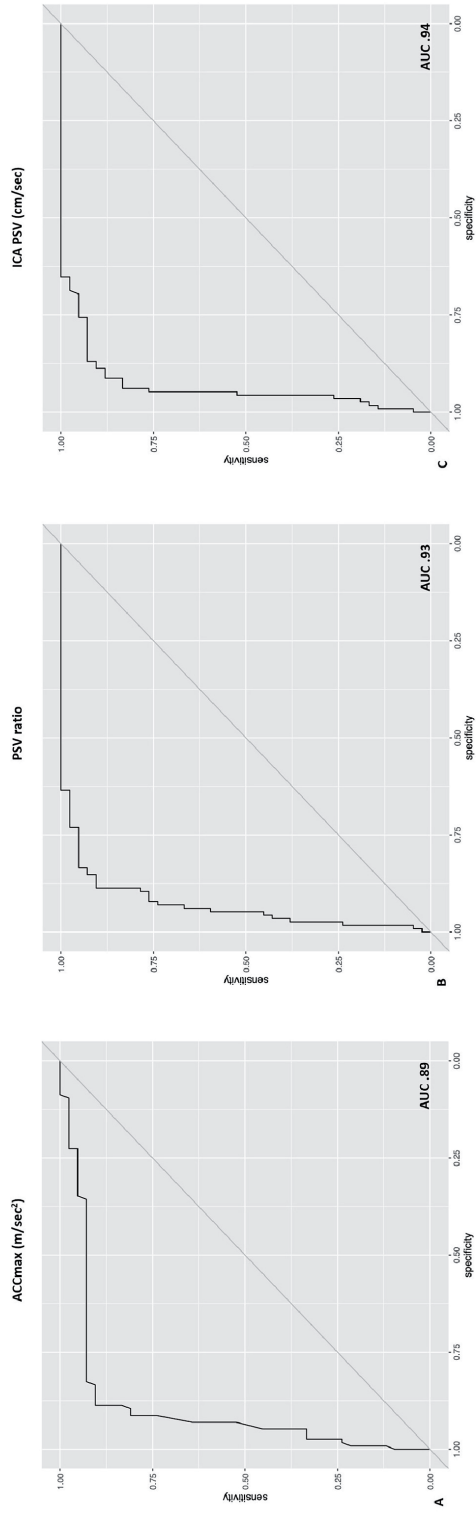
ROC-curves for ACCmax, PSV ratio and ICA PSV for diagnosing  $\geq 70\%$  ICA stenosis. Data of 157 carotid arteries were used for determining the ROC-curves for ACCmax (A), PSV ratio (B) and ICA PSV (C) to diagnose  $\geq 70\%$  carotid stenosis (based on CTA-imaging). The area under the curve (AUC) is given in the figure. ACCmax: maximal systolic acceleration, PSV ratio: peak systolic velocity ratio, ICA PSV: internal carotid artery peak systolic velocity.
